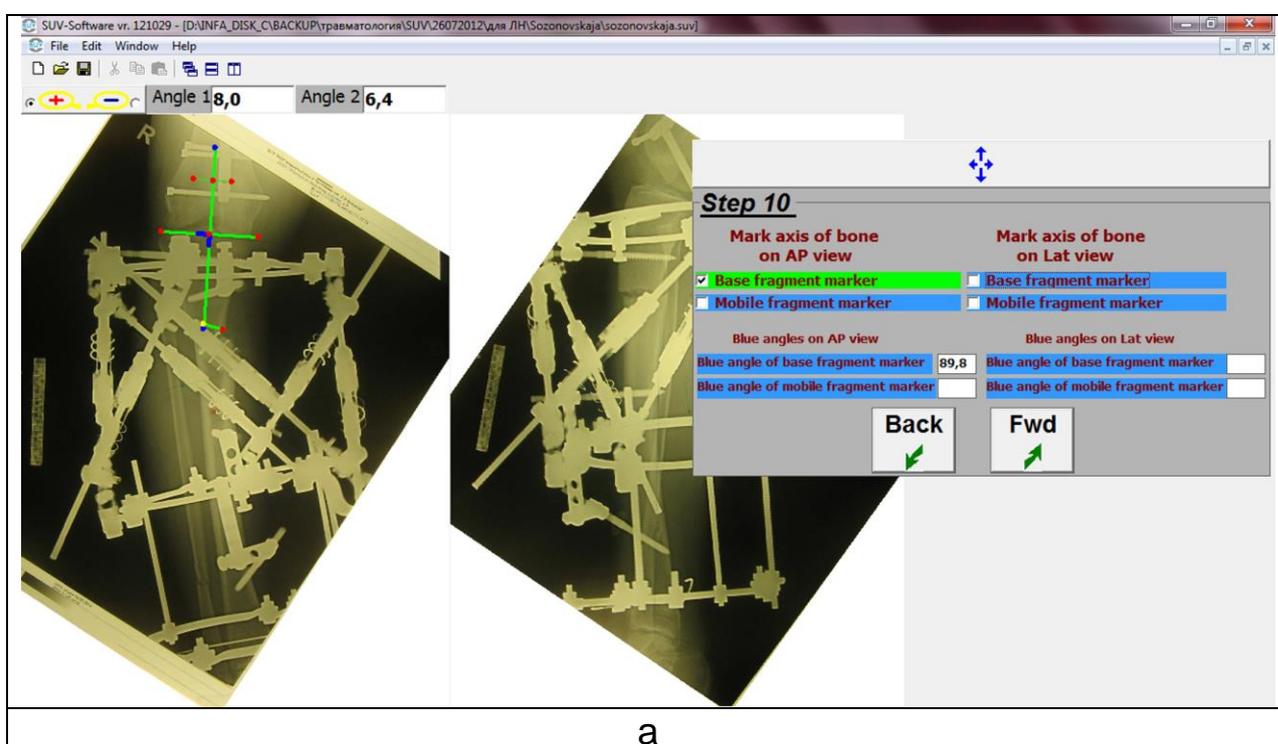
Ortho-SUV software window in Step 10: the features of yellow points setting in presence of gap between bone fragments. a - yellow point of proximal
